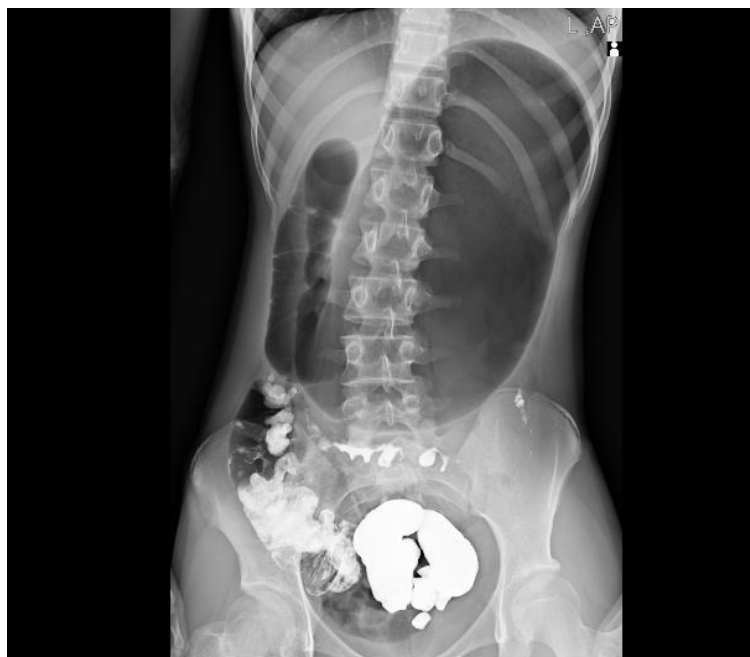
Initial supine radiograph immediately after endoscopic balloon dilation.
